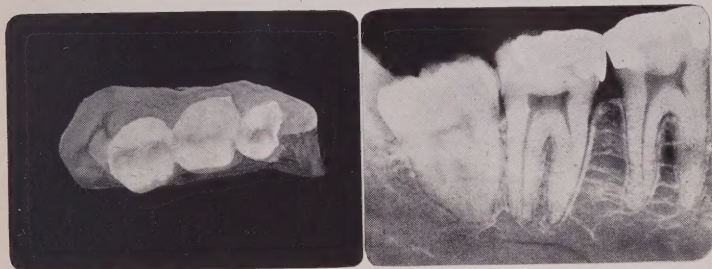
MODEL AND RADIOGRAPH OF PARTLY ERUPTED LOWER LEFT THIRD MOLAR
